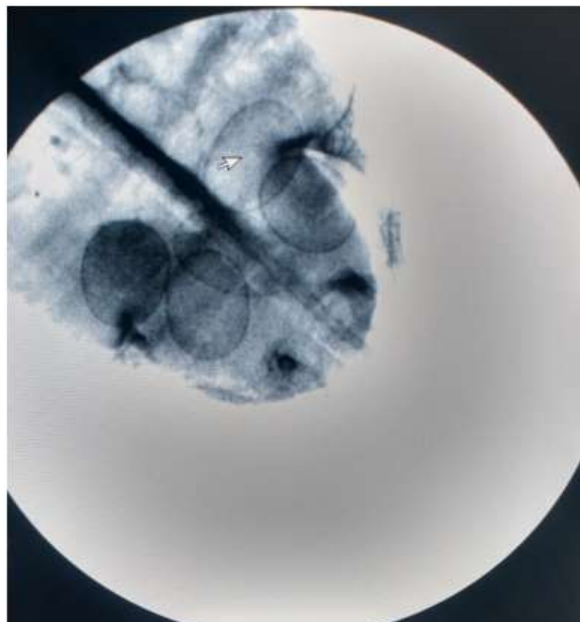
Radiograph reveals five shelled eggs in the oviduct
